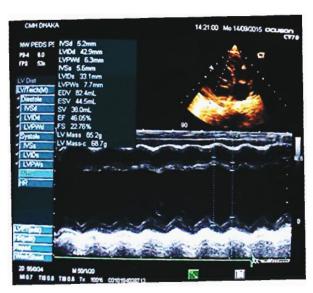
Echocardiography showing dilated LV and poor LV function.
